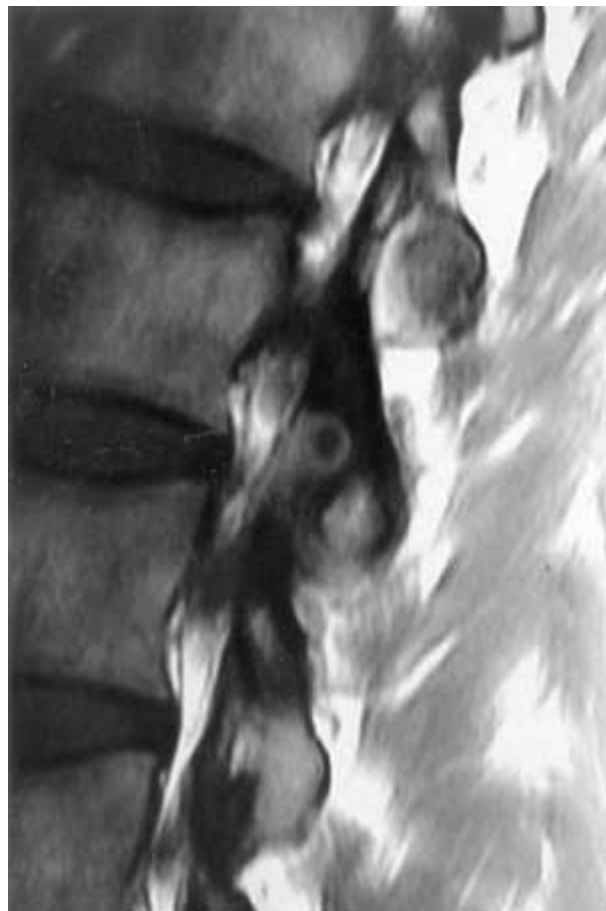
MR image of Case 2 showing the nidus surrounded by oedema and reactive sclerotic bone ; the nidus had not been identified initially.
